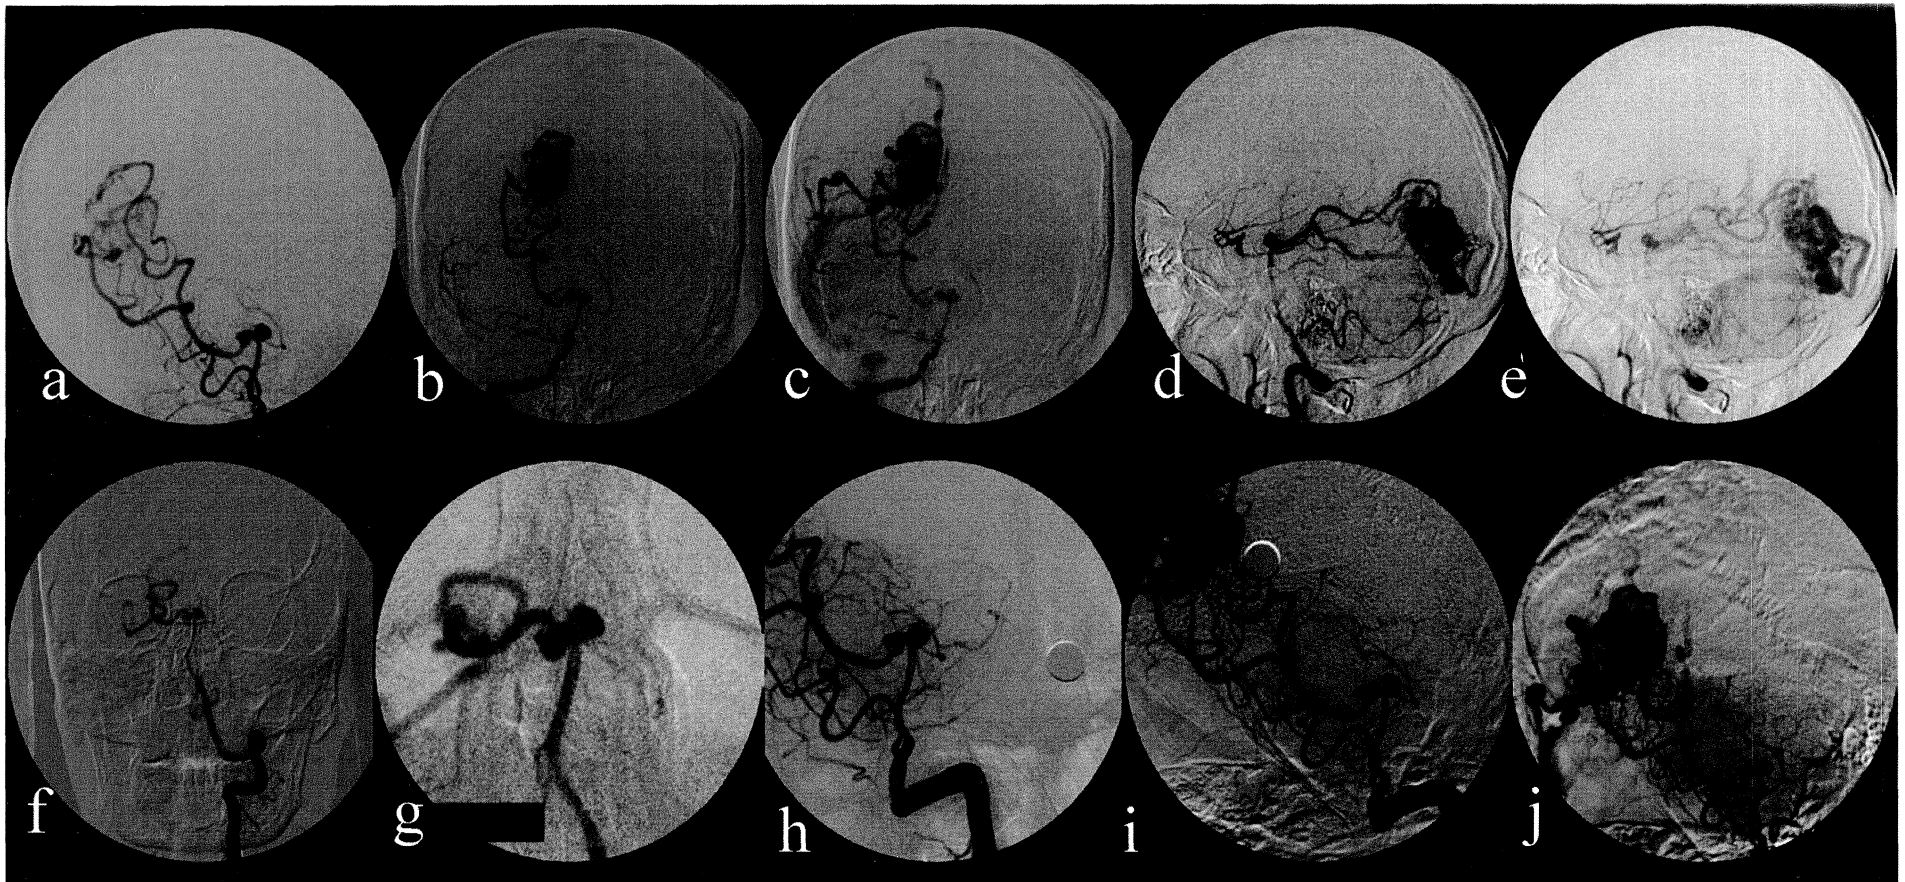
53 year old lady with sudden onset of headache, loss of consciousness and urinary incontinence. CT revealed SAH with right occipital lobe AVM. DSA (a –j) showed a compact nidus (b) in right occipital region measuring 26 x 18 mm with feeders from parieto-occipital and calcarine branches of right PCA (a,d) draining into right transverse sinus and SSS (c,d). There was a basilar quadrifurcation bilobed, saccular aneurysm, projecting superiorly at basilar top measuring 4.6x5.9 mm; with the other aneurysm measuring 5.4x4.7 mm projecting antero-inferiorly (f-j).
